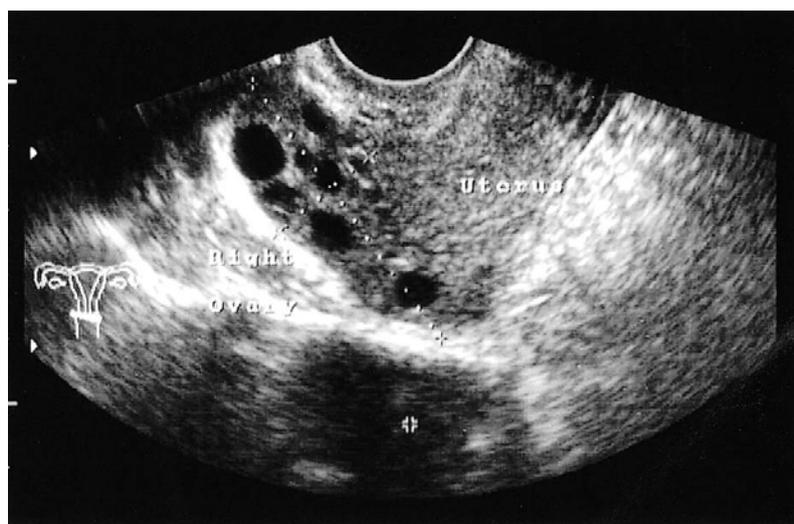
Transvaginal ultrasound shows an enlarged ovary containing numerous different-size follicles and a normal-appearing uterus.
